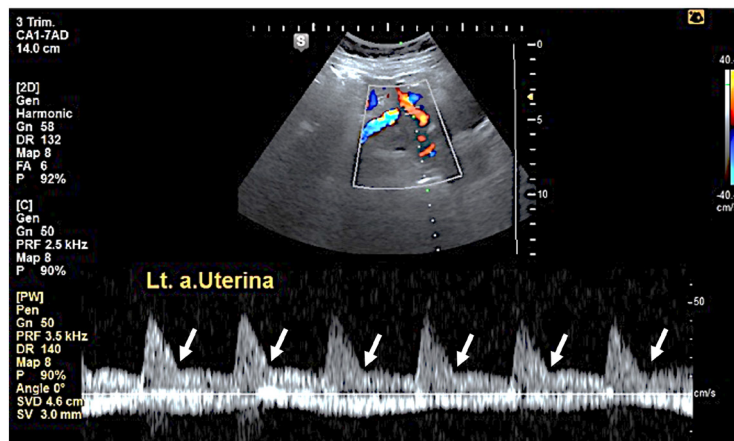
Left uterine artery. Ultrasound examination results for the 7<sup>th</sup> pregnancy, left uterine artery persistent notching at 21st weeks of pregnancy (white arrow).
